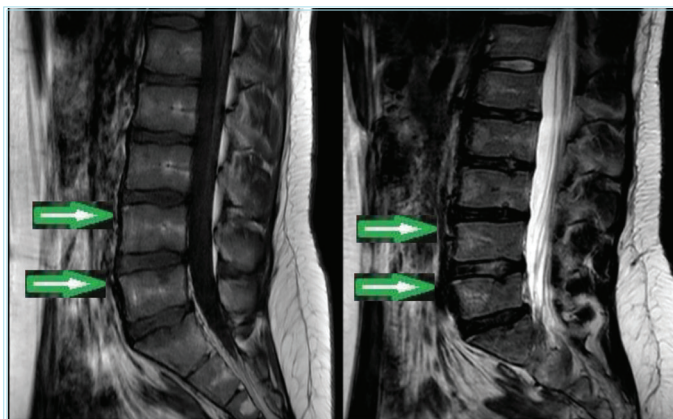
Modic type 2 degeneration is shown on sagittal T1-weighted and T2-weighted images, respectively
